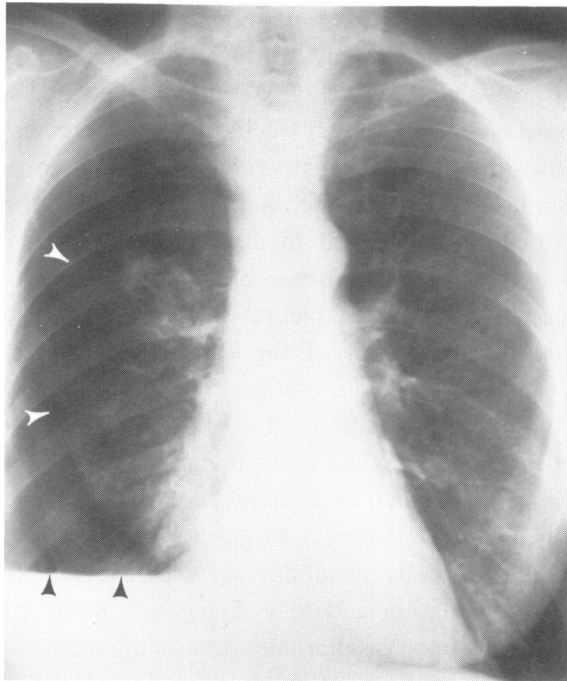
This middle aged woman came to the Emergency Room following right sided blunt chest trauma. The admission radiograph at that time reveals an air-fluid level with a moderate sized pneumothorax. The air-fluid level (black arrowheads) indicates both fluid, probably blood, and air within the pleural space. The pneumothorax is confirmed by identification of the visceral pleural line (white arrowheads).
